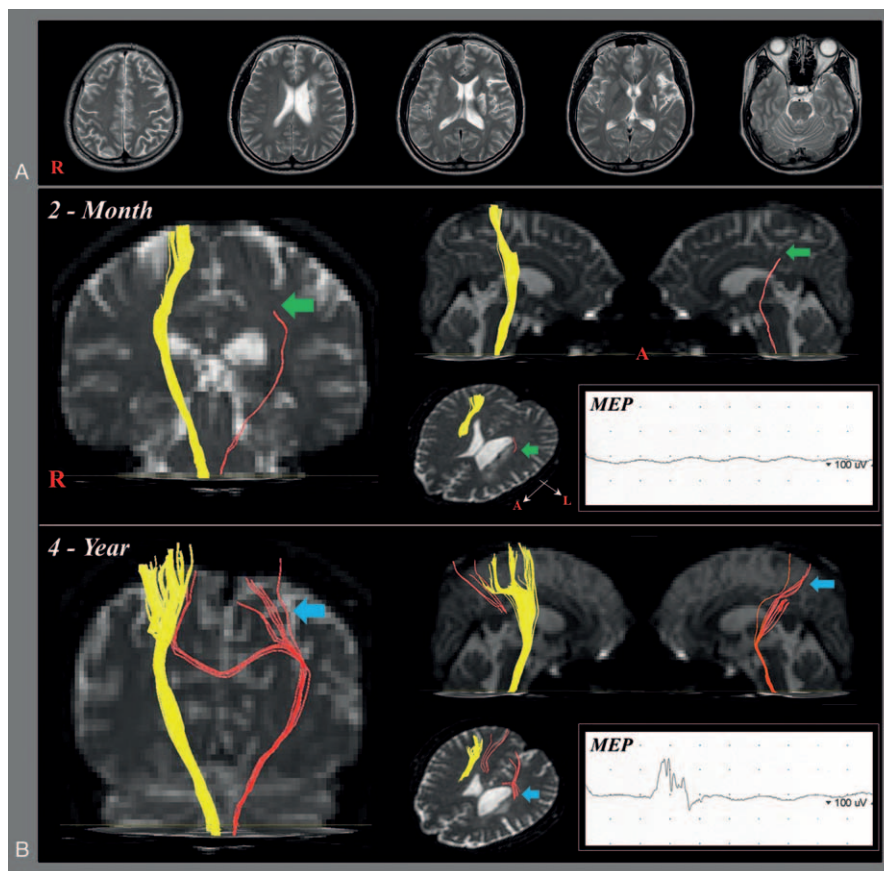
(A) T2-weighted images (2 mo after onset) showing an infarct in the left corona radiata. (B) Results of DTT and TMS. Discontinuation of the left CST at the corona radiata level was observed on 2-mo DTT, however, the integrity of the discontinued left CST had recovered to the primary motor cortex through the posterior area of the corona radiata infarct on 4-y DTT. No MEP was obtained from the right abductor pollicis brevis muscle on 2-wk TMS; however, MEP (latency: 22.3 ms, amplitude: 200 μ V) was evoked on 4-y TMS. CST = corticospinal tract, DTT = diffusion tensor tractography, MEP = motor-evoked potential, TMS = transcranial magnetic stimulation.
